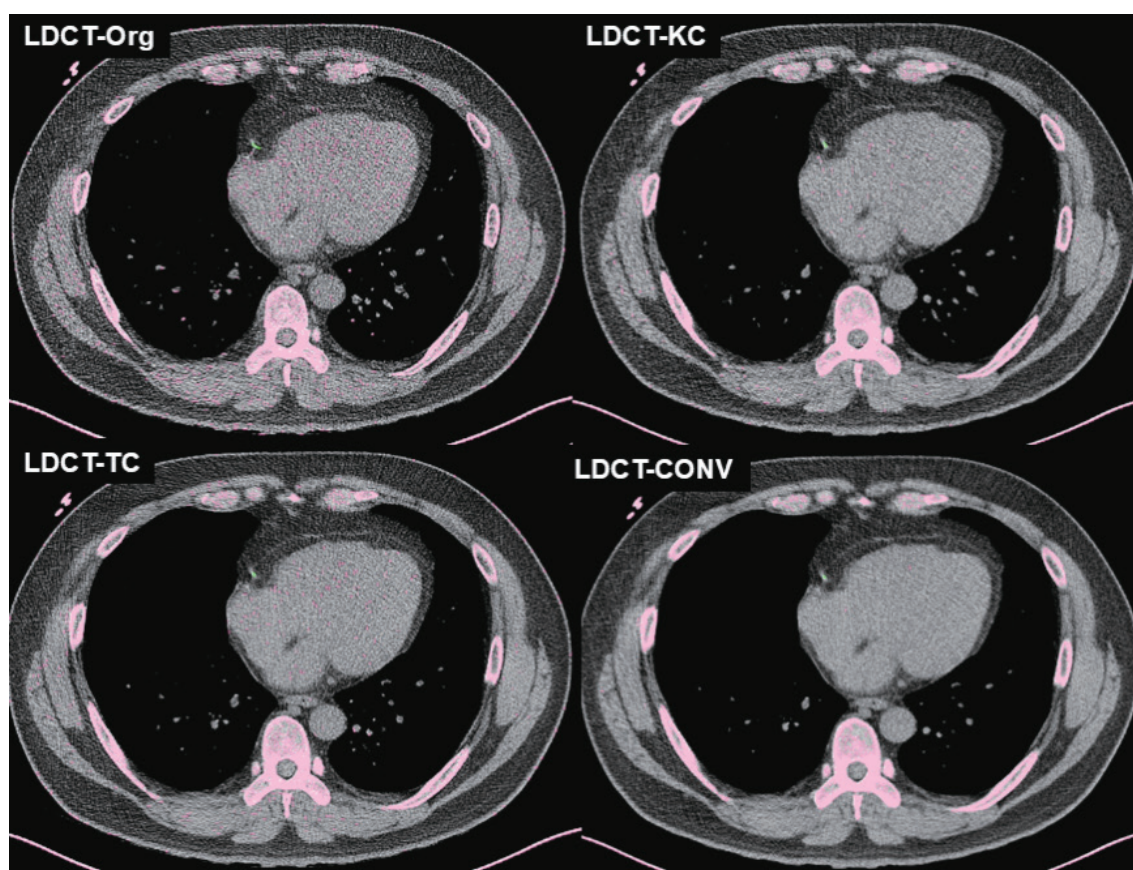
Examples of image conversion. Original image without conversion (LDCT-Org), image with kernel conversion only (LDCT-KC), image with slice thickness conversion only (LDCT-TC), and image with both kernel and slice thickness conversion (LDCT-CONV). The Agatston scores of the reference standard ($\text{CSCT}_{\text{manual}}$), LDCT-Org_{auto}, LDCT-KC_{auto}, LDCT-TC_{auto}, and LDCT-CONV_{auto} were 56, 106, 64, 67, and 58, respectively. LDCT = low-dose chest computed tomography, LDCT-Org = original image without conversion, LDCT-KC = LDCT image with kernel conversion only, LDCT-TC = LDCT image with slice thickness conversion only, LDCT-CONV = LDCT image with both kernel and slice thickness conversion, CSCT = calcium scoring computed tomography, $\text{CSCT}_{\text{manual}}$ = manual scoring on calcium scoring CT, LDCT-Org_{auto} = automatic scoring on original LDCT images without conversion, LDCT-KC_{auto} = automatic scoring on LDCT images with kernel conversion, LDCT-TC_{auto} = automatic scoring on original LDCT images with slice thickness conversion, LDCT-CONV_{auto} = automatic scoring on LDCT images with both kernel and slice thickness conversion
